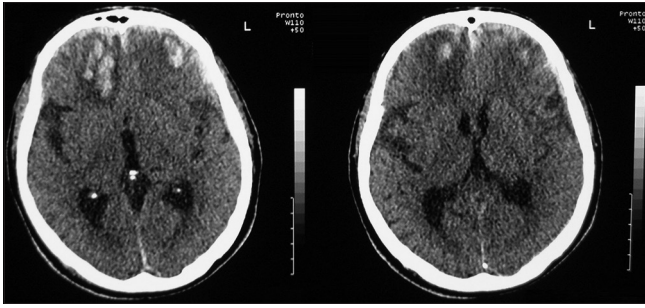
Cranial computed tomography revealed bifrontal cerebral contusions with minimal subdural hematoma
